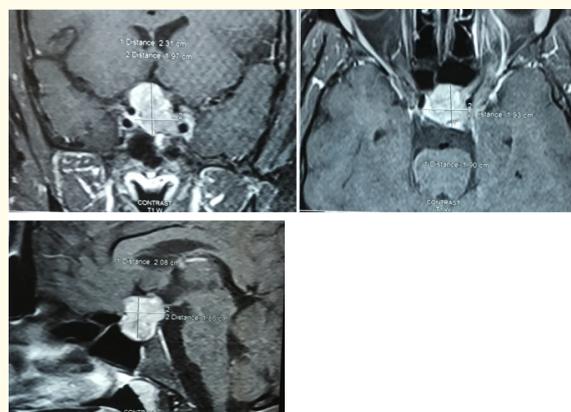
Preoperative MRI showing suprasellar extension of pituitary macroadenoma.
